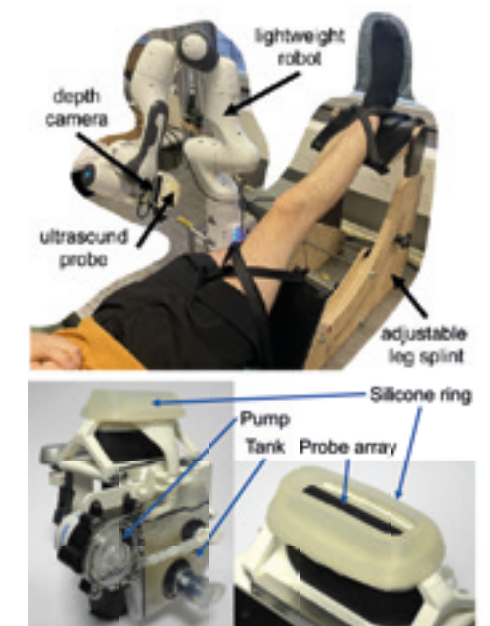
a) Autonomous robotic ultrasound scanning of the knee; b) automatic contact gel applicator prototype.
